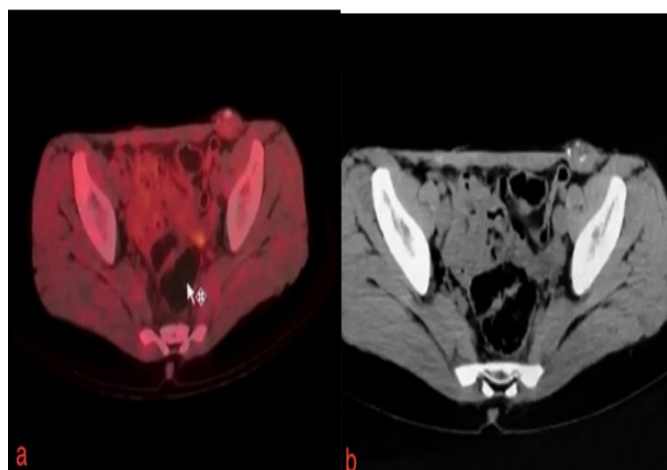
F-18 FDG PET/CT images at the end of chemotherapy. Fusion image (a), CT image (b)
